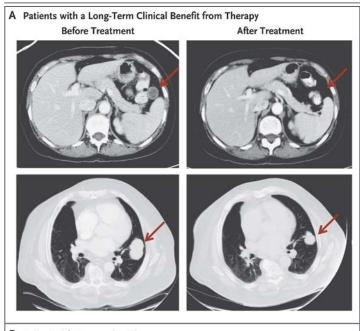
Paired Pretreatment and Post-Treatment Computed Tomographic Scans
